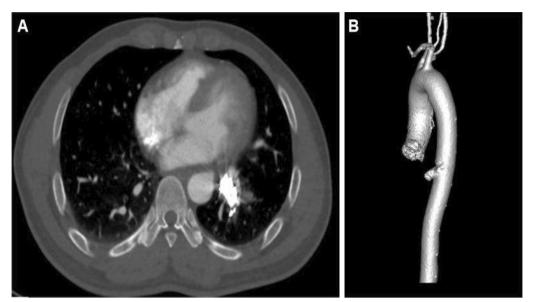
Combined CTA of the aorta and pulmonary artery on postoperative day 1: A Striated and patchy low-density filling defects accompanied by high-density coils in the proximal segment of the anomalous artery. B VR reconstruction of the aorta demonstrates that the distal segment of the anomalous artery is not visible, indicating successful embolization
